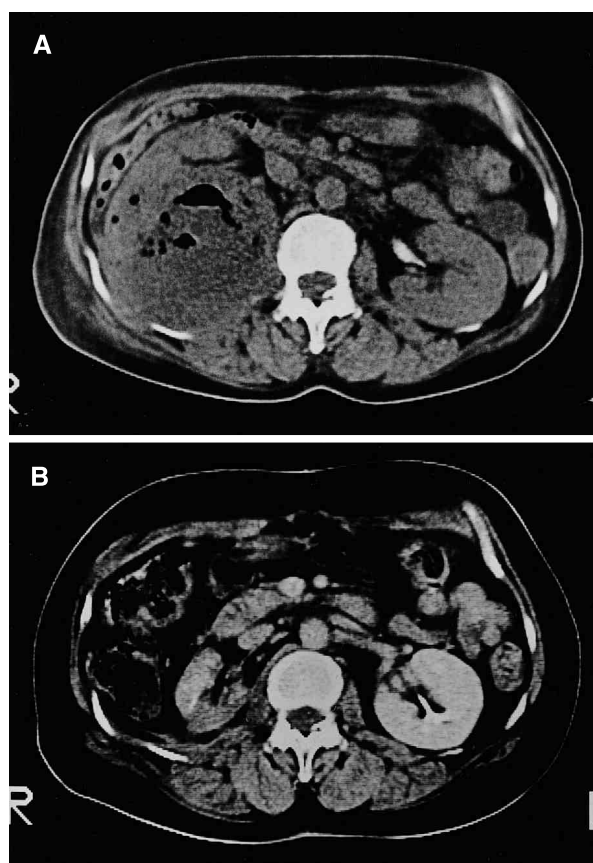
CT scans of right renal cell carcinoma before (A) and 4 months after one-shot chemoembolization with 30 mg MMC microcapsules (B). A complete response of the large tumor is apparent
